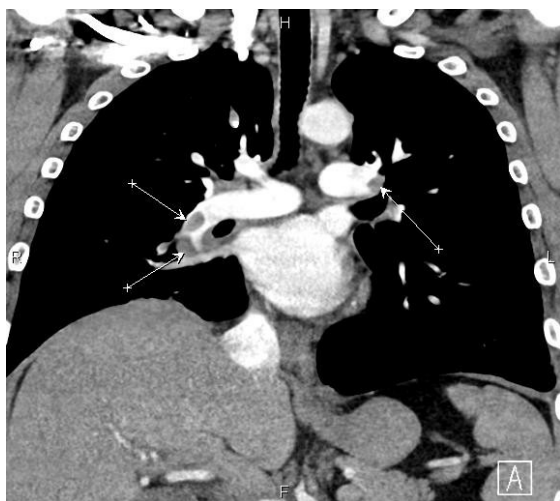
Coronal contrast-enhanced computed tomography pulmonary angiography showing bilateral pulmonary arterial filling defects consistent with pulmonary emboli (arrows).
